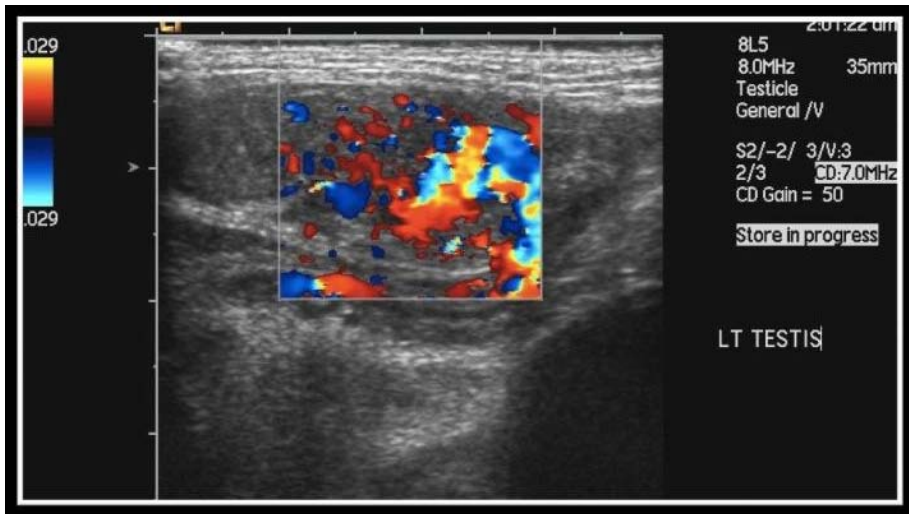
Ultrasound of the left testis which demonstrates an increase in doppler signal within the testis. The left testis is in the inguinal canal.
